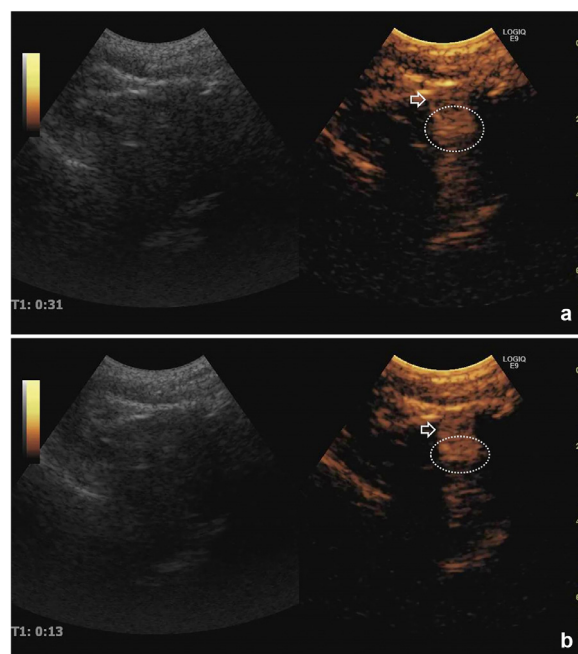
The effect of hemostasis of SL group. (a) After the injection of the SL, we kept on observing by the transcranial CEUS for 10 s. At the 10 s after the local drug therapy, we could also clearly identify the image of ICH (as shown by the white dotted circle) and active bleeding (as shown by the white arrow). (b) We observed the ICH again by the transcranial CEUS after the first contrast agents totally disappeared and the image of ICH (as shown by the white dotted circle) and active bleeding (as shown by the white arrow) were still clearly identified, which strongly suggested that the hemostasis by SL injection was ineffective. SL = saline; CEUS = contrast-enhanced ultrasound; ICH = intracerebral hematoma.
